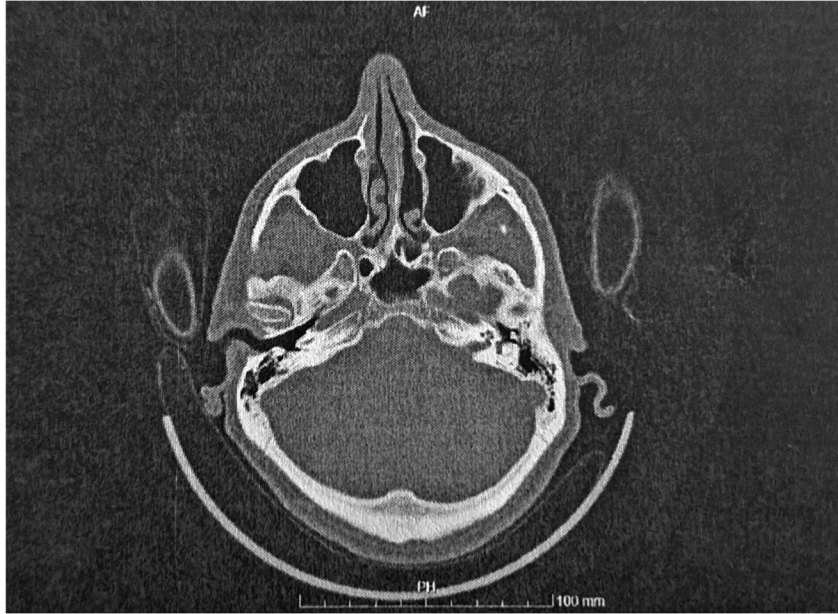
Head CT scan, without contrast, performed in an acute episode of dizziness and gait abnormalities, showing an expansive lesion in the left internal auditory meatus extending to the cerebellopontine angle, with less than 1cm in size. Performed after left nasal fossa polypectomy.
